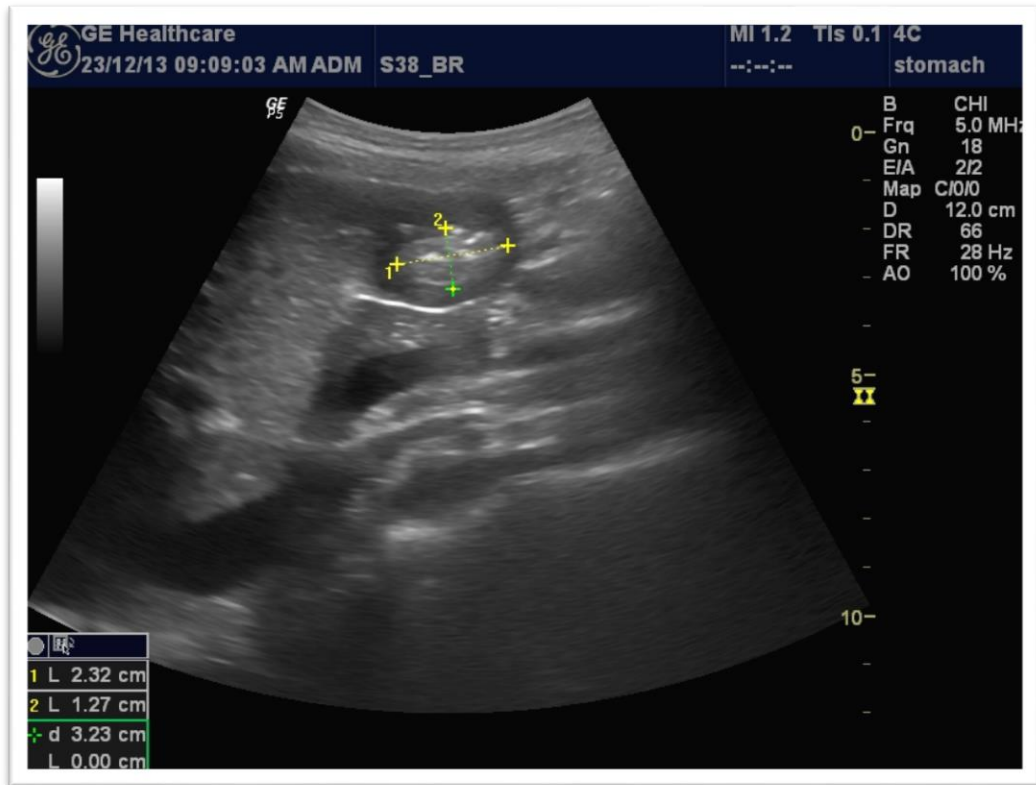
1 Ultrasound photo of gastric antrum at fasting
